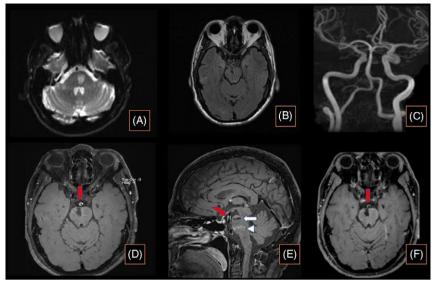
MRI and Vessel wall imaging for the patient. A) Diffusion-weighted MRI showing acute left paramedian pontine infarct. B) FLAIR MRI from the same study in A showing chronic superior right paramedian pontine infarct. C) Circle of Willis Time of Flight MRA showing patent Basilar artery. D & E) Enhanced vessel wall imaging-MRI axial sections showing concentric enhancement of the Basilar artery (red arrow) as well as the old (white arrow) and new (arrowhead) pontine infarcts. F) Follow-up images showing improvement in the basilar artery enhancement (red arrow) following immunosuppressive therapy.
